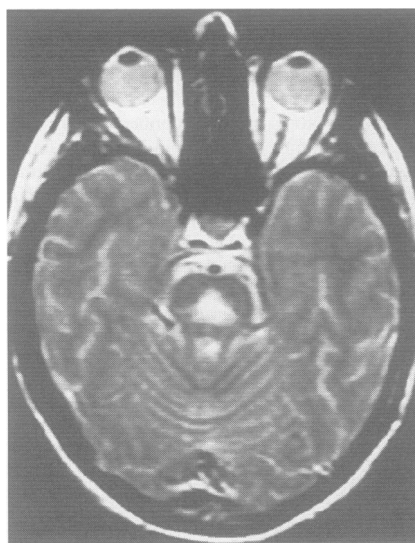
T2 weighted MRI showing high signal symmetric lesion in the centre of the pons, characteristic of central pontine myelinolysis.
